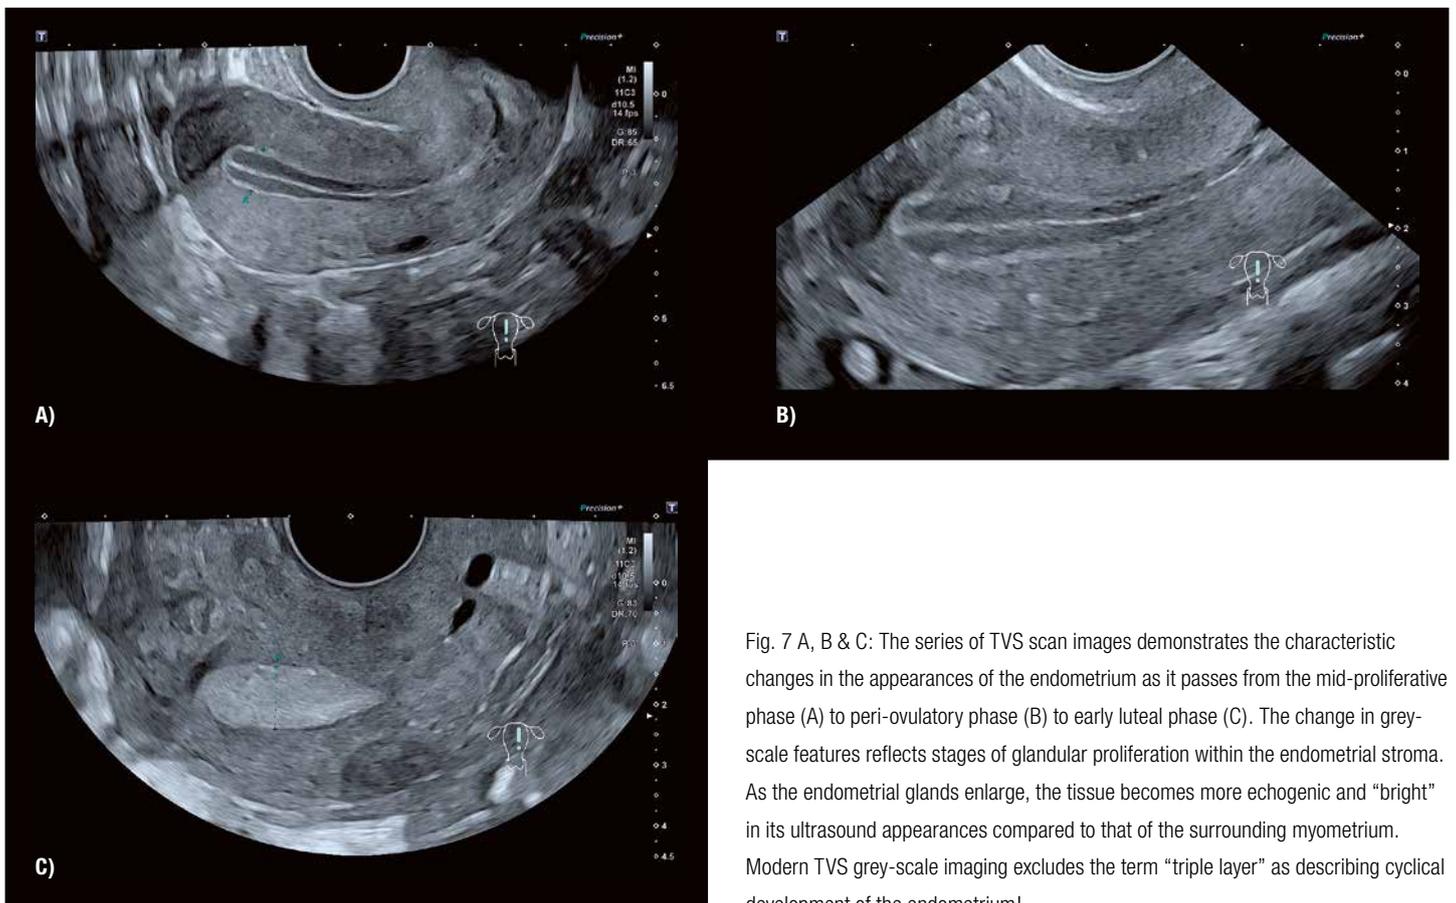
A, B & C: The series of TVS scan images demonstrates the characteristic changes in the appearances of the endometrium as it passes from the mid-proliferative phase (A) to peri-ovulatory phase (B) to early luteal phase (C). The change in grey-scale features reflects stages of glandular proliferation within the endometrial stroma. As the endometrial glands enlarge, the tissue becomes more echogenic and “bright” in its ultrasound appearances compared to that of the surrounding myometrium. Modern TVS grey-scale imaging excludes the term “triple layer” as describing cyclical development of the endometrium!
